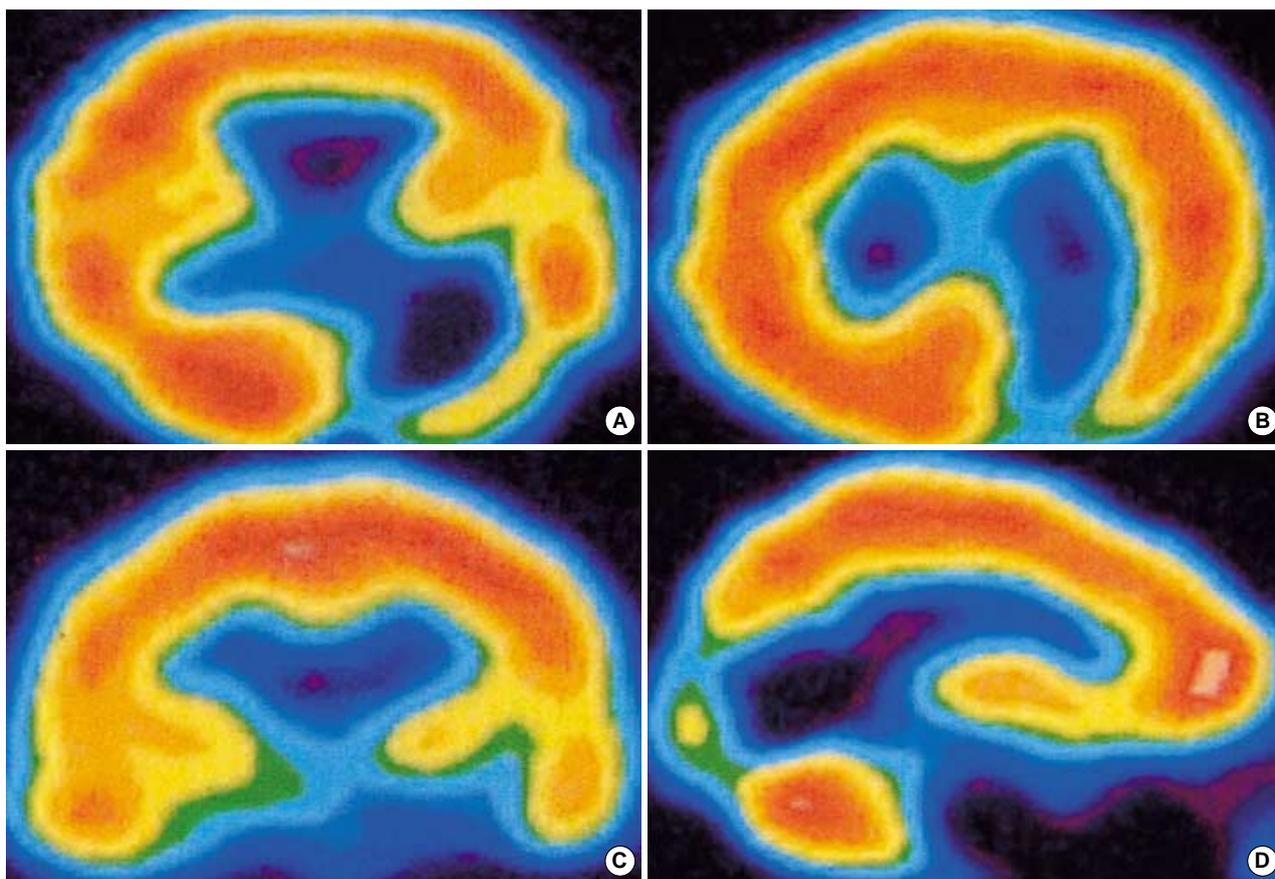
^{99m}Tc -HMPAO SPECT showing markedly reduced perfusion in left temporo-occipital areas. Axial (A, B), coronal (C), and sagittal (D) images.
